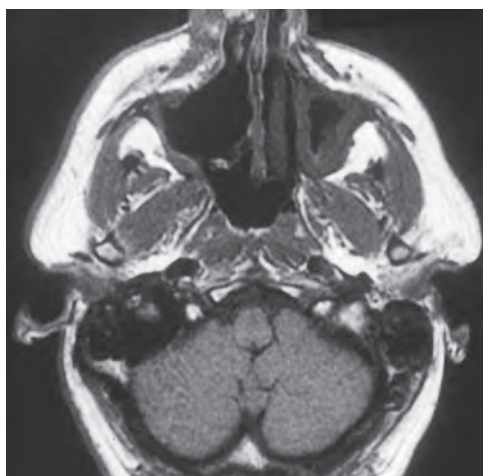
An axial view of the magnetic resonance imaging scan shows a honeycomb-like tumor in the nasal cavity and right maxilla.
